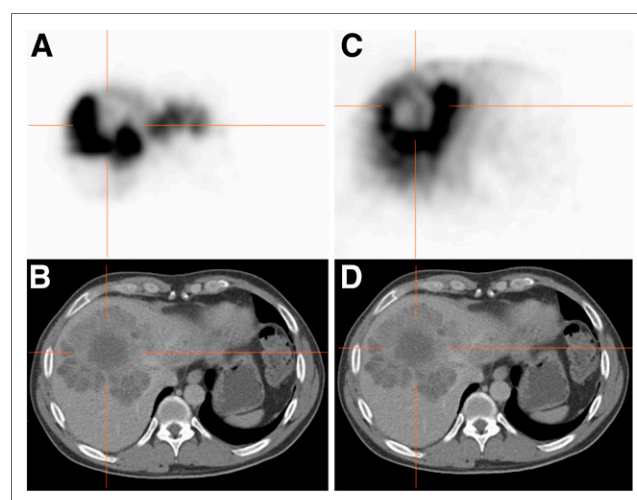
<sup>99m</sup>Tc-MAA SPECT (A) and SPECT/CT (B) images and post-<sup>90</sup>Y radioembolization bremsstrahlung SPECT (C) and SPECT/CT (D) images in 65-y-old woman with MAM. Lesions with grade 1 uptake on <sup>99m</sup>Tc-MAA SPECT show no uptake on <sup>90</sup>Y radioembolization image.
